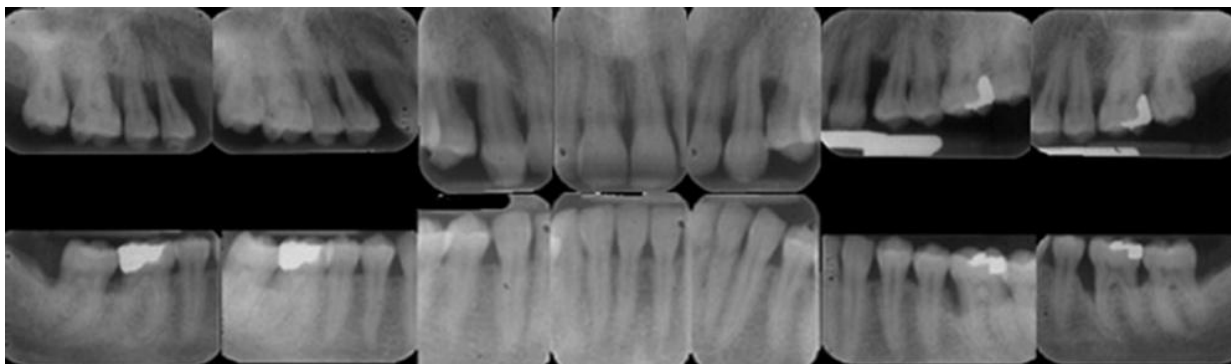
Radiographs of the patient presented in Fig. 32-2.
